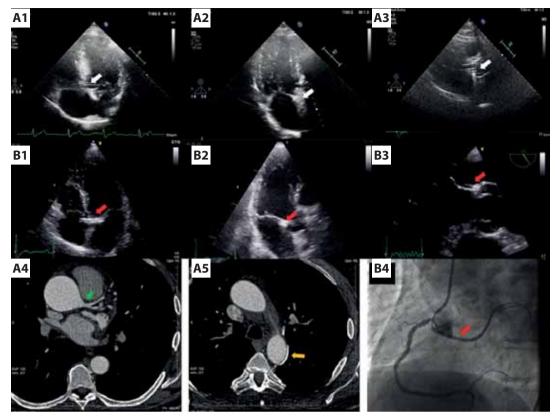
Apposition of the images of a mechanical bileaflet aortic valve presenting a "crossed aorta" sign despite normal anatomy of the origin and proximal course of the left CA (images labeled with letter A) with the images (from another patient) of anomalous origin of the circumflex CA from the right coronary artery forming a true positive for the retroaortic course of the CA "crossed aorta" or RAC sign as well as a "bleb sign" on a transesophageal study (images labeled with letter B). A1-A3. False-positive or pseudo-crossed aorta sign. A1. Crossed aorta sign (white arrow) in the apical view. A2. Echo shadow originating from the posterior aortic valve disc obliterates the retroaortic region at the base of the mitral leaflet when the presence of a "bleb sign" should be assessed (white arrow). A3. The opened mechanical aortic discs form parallel lines inside the aortic lumen in the long-axis parasternal view during systole (white arrow). B1-B3. Special version of a true positive crossed aorta sign (with coronary stent inside). B1. Crossed aorta sign (red arrow) in the apical view, image is formed by the retroaortic course of the circumflex CA which additionally has a stent implanted in its proximal part enhancing the image of the vessel wall (B2) Cross-section of the stented retroaortic circumflex artery is visible as hyperechogenic speckle in the aorto-mitral angle (red arrow) (B3) the same region examined with better resolution on transesophageal echocardiography shows very clearly cross-section of the anomalous circumflex artery with an implanted stent, forming a special version of stented "bleb sign" with the hypoechogenic vessel lumen inside the hyperechogenic ring (red arrow). A4. Normal origin and division of the left main CA on CT examination performed before Bentall surgery (green arrow). A5. Additional vessel coursing in the posterior region of the descending aorta visible in the contrast phase of the CT study assessed as a collateral vessel without clinical significance for coronary circulation — for this vessel, however, the probability of it being responsible for forming the crossed aorta sign was assessed by a radiologist as low (yellow arrow). B4. Coronary angiography of the patient with a true crossed aorta and bleb sign documenting the retroaortic course of the circumflex CA originating from the right CA. Some images shown in panels B were published previously in [1]
